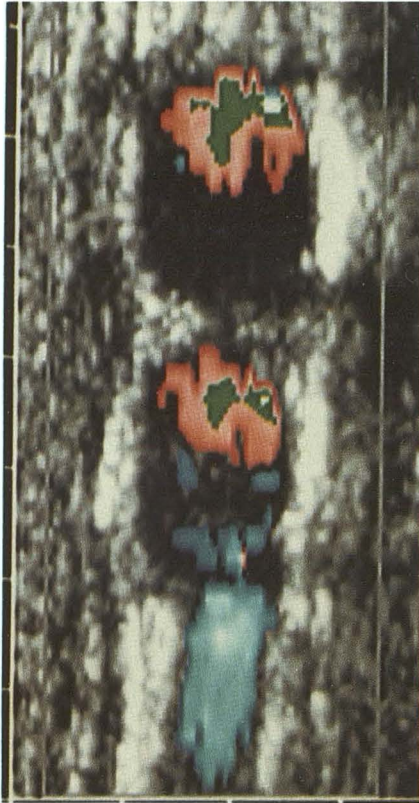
Color Doppler of lateral tandem control aneurysms, inflow (red), outflow (blue), color encoded for velocity with higher velocities in green and the highest velocities in white, demonstrating a central discreet high velocity jet within the inflow zone.
